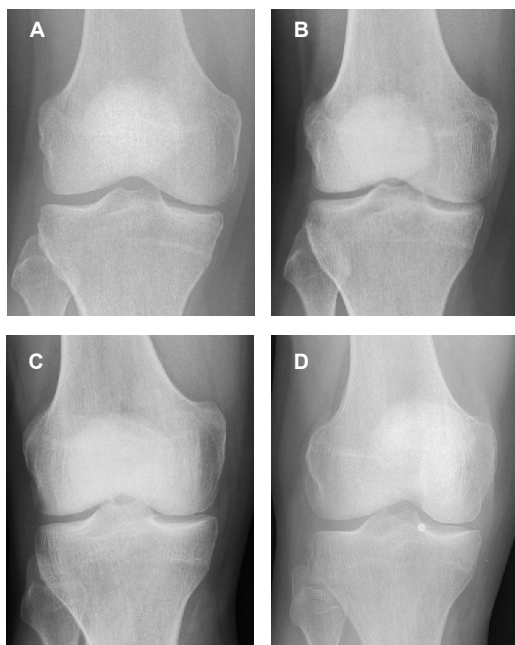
Examples of disagreement between KIDA measurement and Altman grading due to radiographic position. Evaluation of change in medial JSN from baseline (A, C) to two-year follow-up (B, D). A-B OA increase according to Altman and no change according to KIDA; C-D no change according to Altman and OA increase according to KIDA
